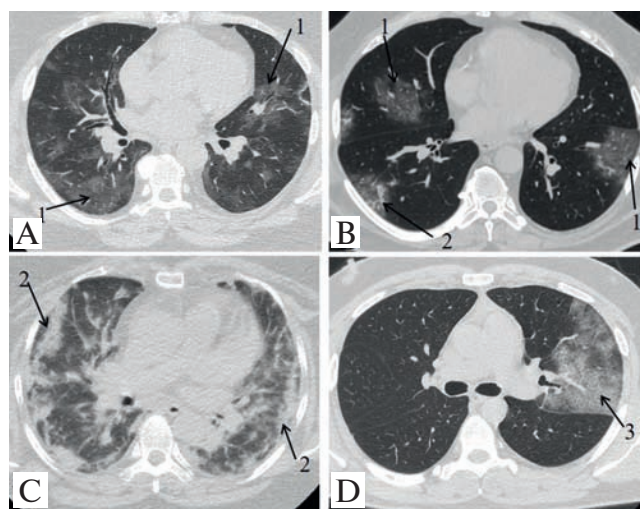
Variants of manifestation of COVID-19 (computed tomography on the 5–7th days of the disease): A, bilateral subpleural and peribronchovascular ground glass foci (1) of irregular shape; B, bilateral ground glass foci (1) with small consolidation areas (2) located subpleurally and in the central areas of lungs; C, bilateral subpleural confluent round areas of consolidation (2); D, crazy paving sign (3) in the upper left lobe
